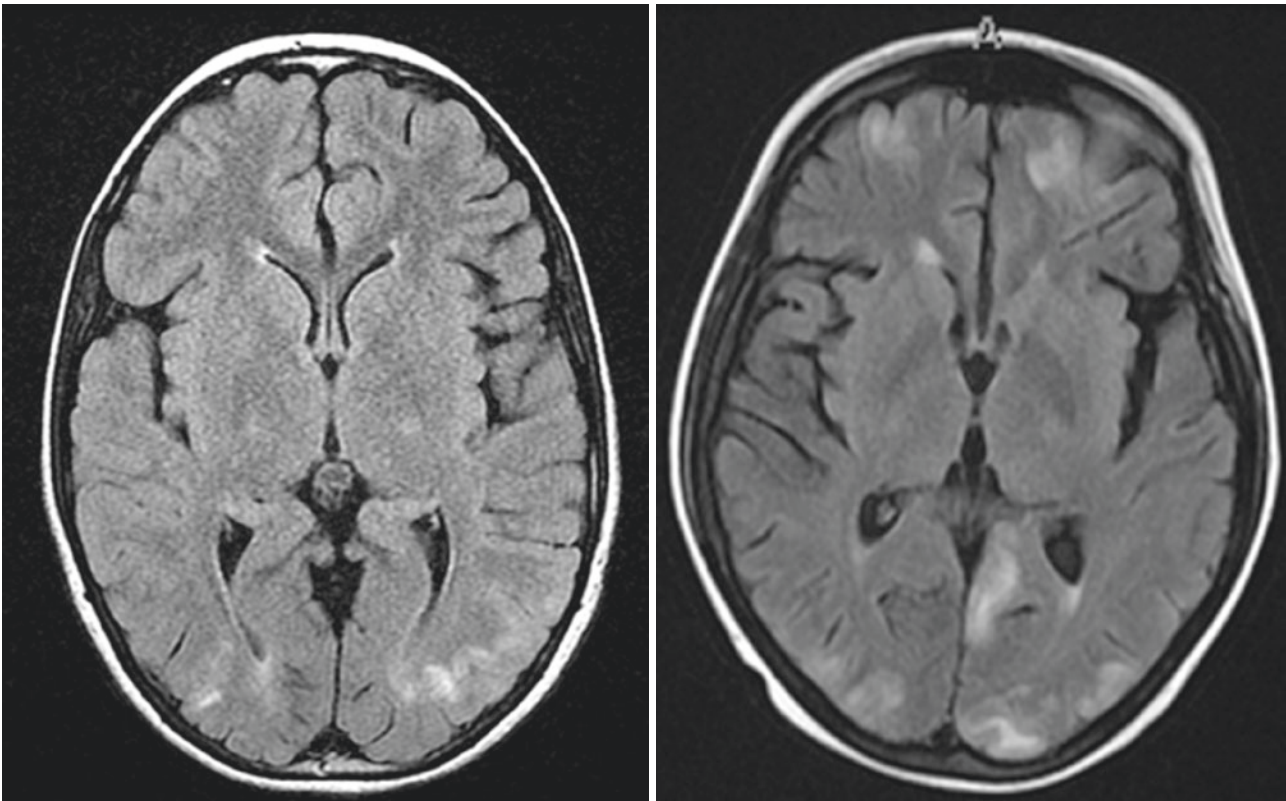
Two patients with clinical and neuroimaging findings consistent with RPLS. Patient 1 (*left*) presented with somnolence, mild hypertension, and a generalized seizure following induction chemotherapy for lymphoma. MRI T2 FLAIR revealed bilateral occipital white matter edema. Patient 2 (*right*) presented with severe hypertension and neurologic changes progressing to deep coma. The patient was receiving high-dose steroids for immunosuppression. MRI T2 FLAIR revealed multiple areas of increased signal intensity indicating vasogenic edema involving the cortices of the frontal lobes, along the watershed territory, and the cortices of the temporal, parietal, and occipital lobes bilaterally
